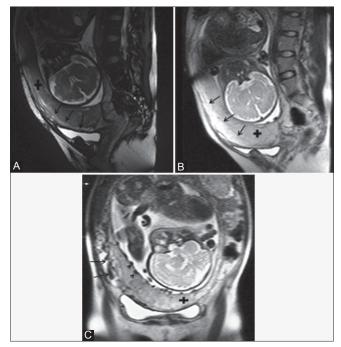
(A-C): Partial placenta previa in a 28-year-old woman at 34 weeks of gestation. (A, B) Sagittal True FISP and T2 HASTE MR images show a homogeneous placenta (+) with smooth distinct placenta-myometrium interphase (arrows) and triple-layered appearance of normal myometrium. The clarity and sharpness of the interphase is superior in the TrueFISP images. (C) Coronal T2 HASTE MR image shows a homogeneous placenta (+) with multiple normal chorionic vessels subamniotically at fetal surface (arrowheads) and increased subplacental vascularity (arrows)
